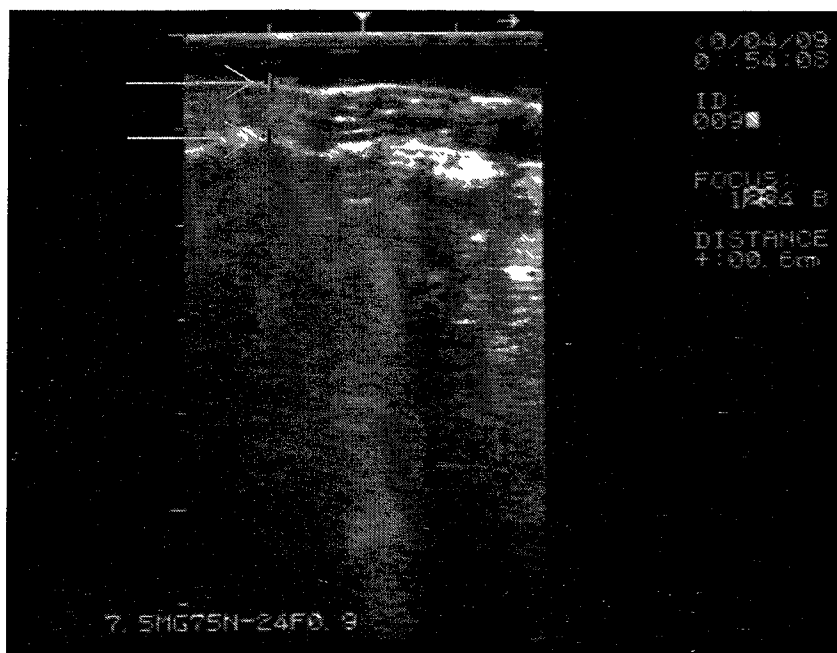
An example of a sonogram showing the author's forehead. The arrows indicate the crosshairs ("+") of the electronic callipers that can be used to measure tissue depth when examining facial landmarks. The distance (6 mm) between the two crosshairs is displayed to the right of the image.
